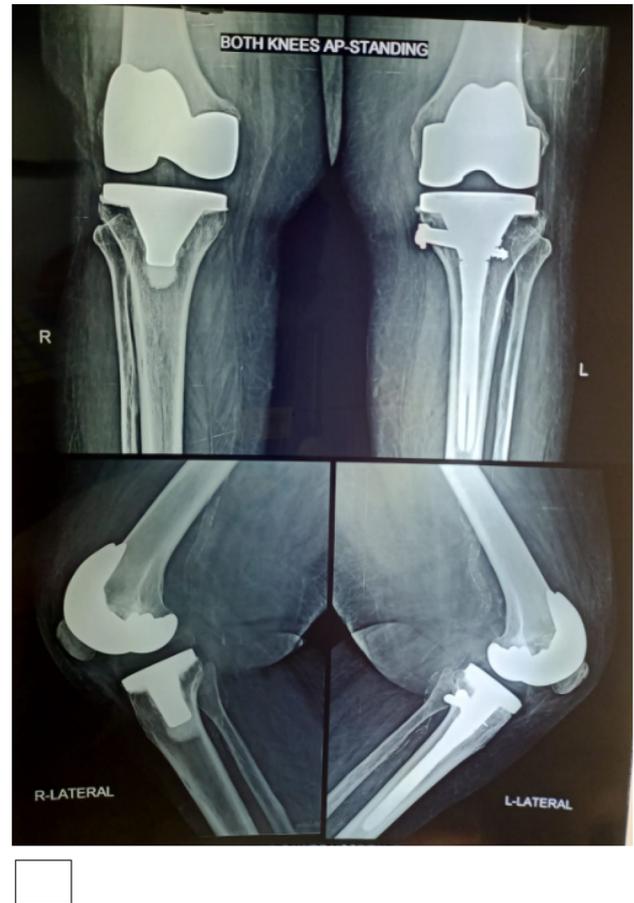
Post-operative X-rays at 5-year follow-up
